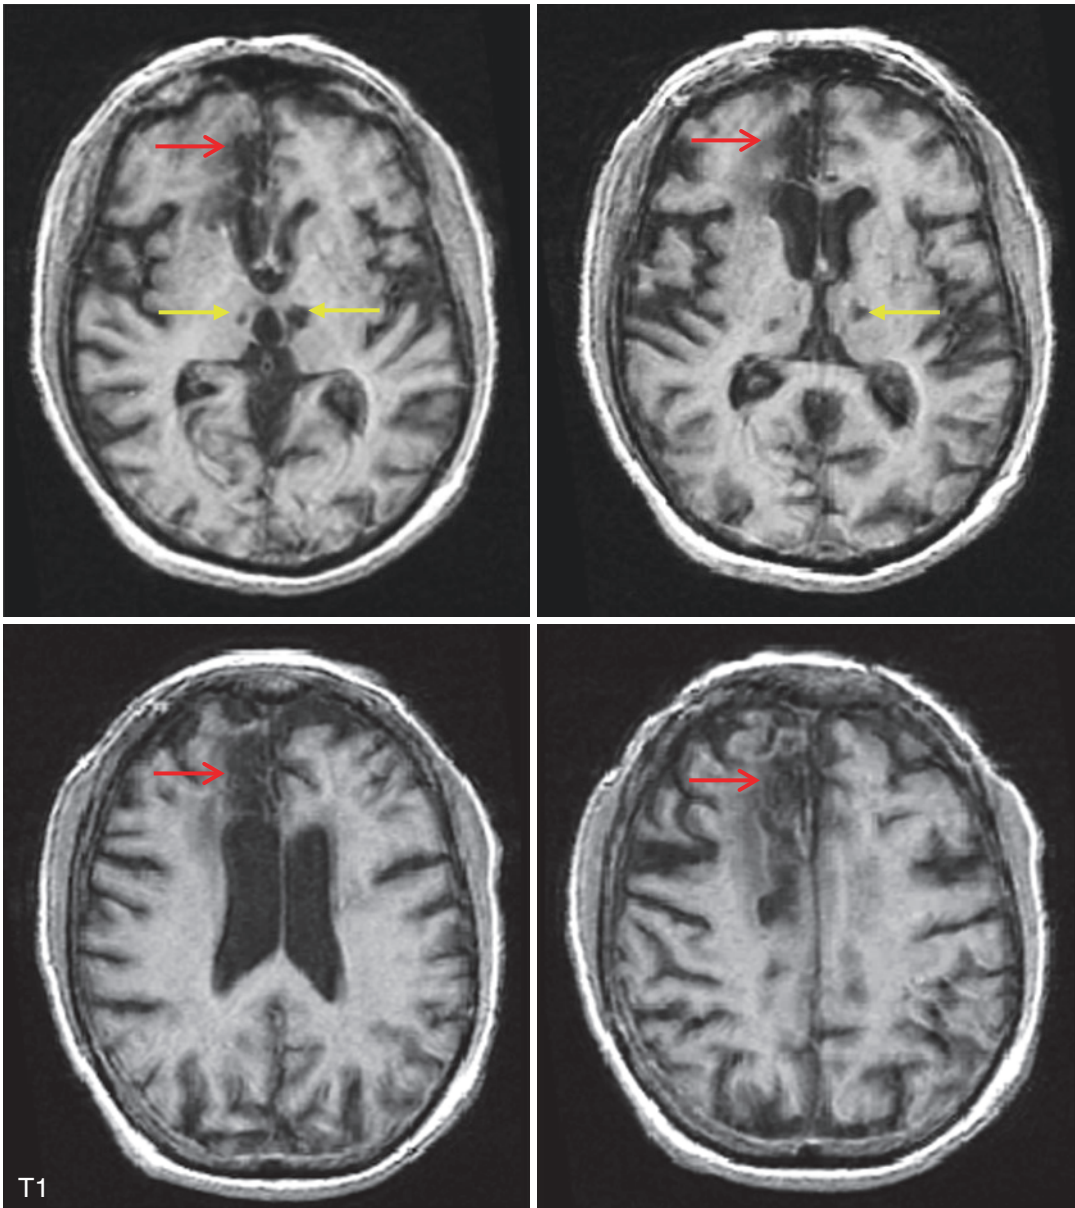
A T1-weighted MRI of a 70-year-old woman with multi-infarct dementia who suffered bilateral dorsal medial thalamic infarcts (yellow solid arrows) causing marked short-term memory loss, followed by a right
